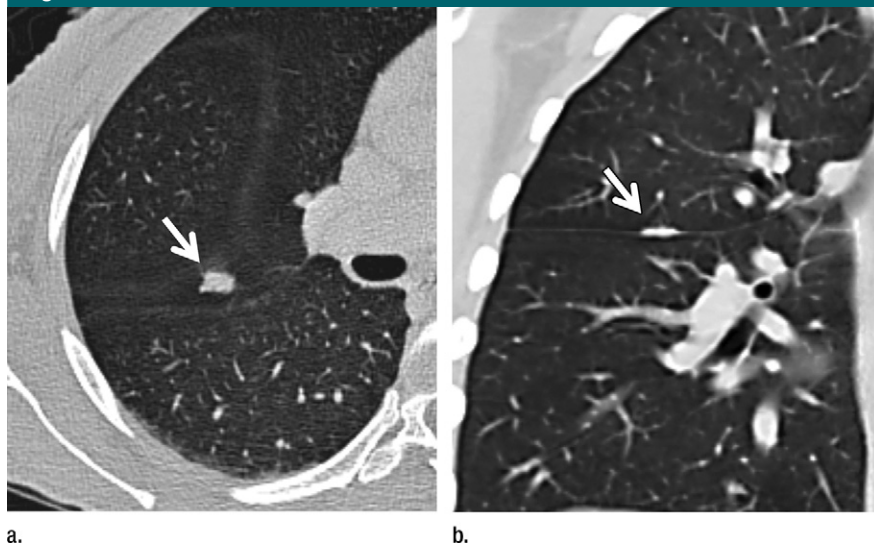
(a) Transverse 1-mm CT section shows a nodular opacity adjacent to the minor fissure (arrow). (b) Coronal reconstructed CT image shows that the opacity is a benign linear scar or lymphoid tissue (arrow).
